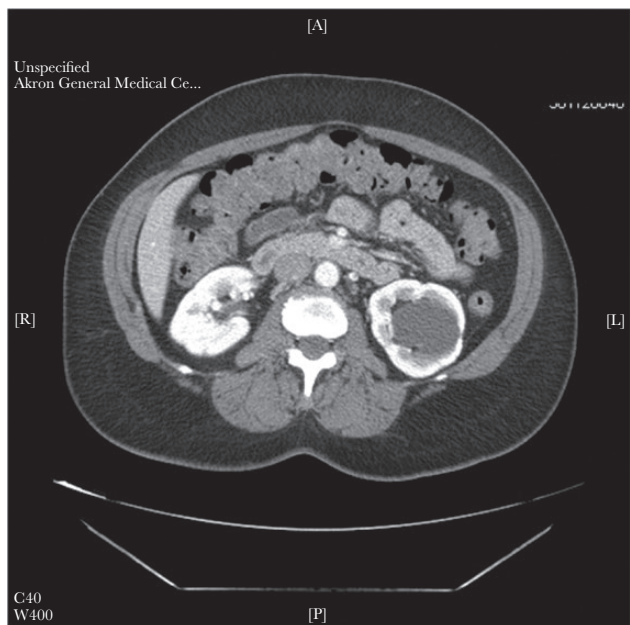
Follow-up computed tomography image showing resolution of the *Mycobacterium chelonae* right renal abscess.
